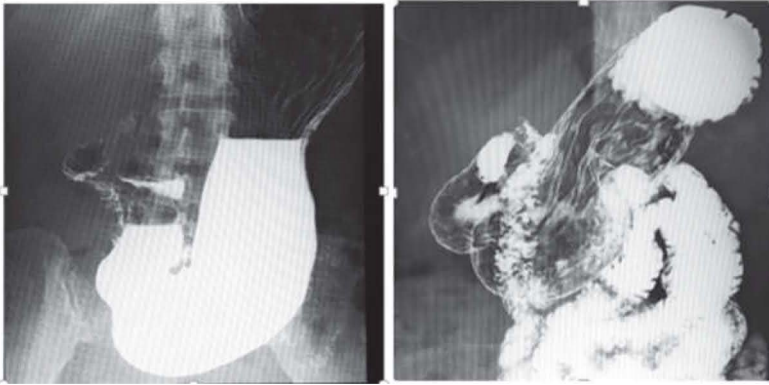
Two motility differences in the stomach, visualized using barium meal/x-rays: constipation (left) and diarrhea (right) (Uno's personal data)*
